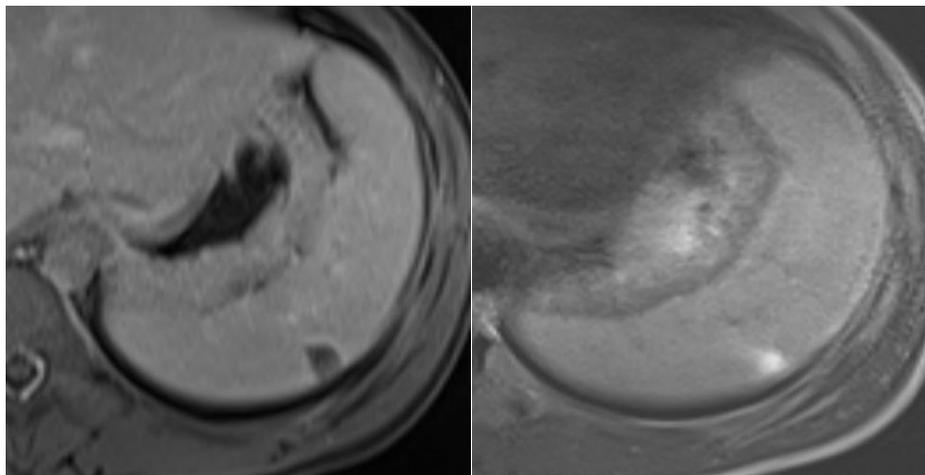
Abdomen magnetic resonance imaging (T1 and T2 weighted, respectively): Splenic focal areas of signal alteration, with prevalent peripheral subcapsular distribution.
